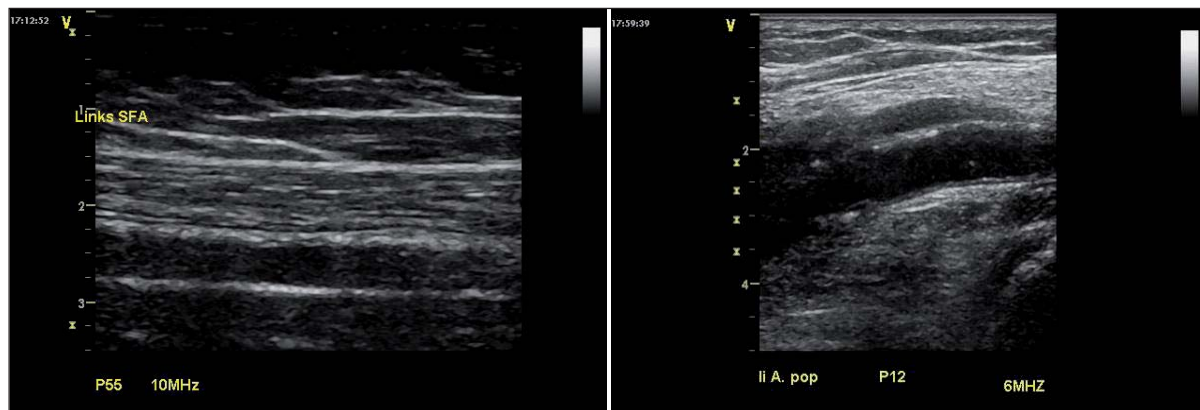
B-mode ultrasound images of the femoral (left) and popliteal (right) arteries. Media with heterogeneously echogenic stripes adjacent to the intima are clearly visualized in both images.
